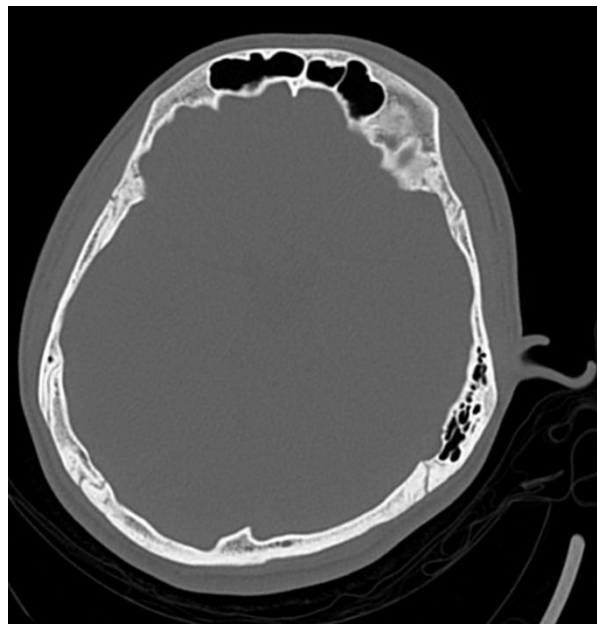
CT brain at bone windows at the level of frontal sinus
